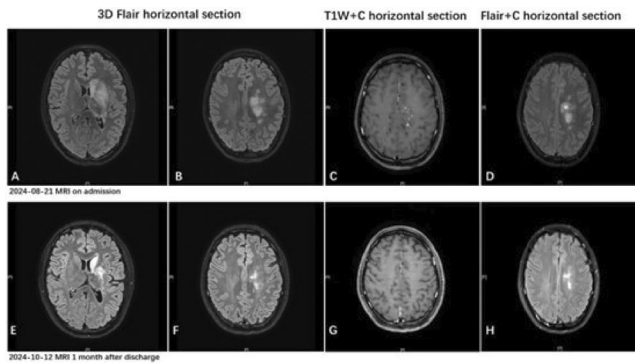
The MRI at admission, the review MRI during hospital stay, and the review MRI at one month post-discharge.
